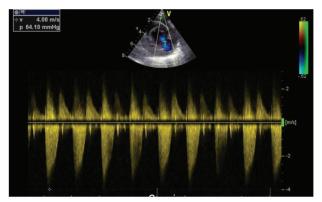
Pulse wave doppler interrogation showing to and fro flow of blood into the pseudoaneurysm through the narrow neck
